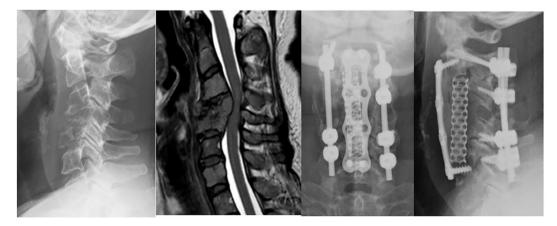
Radiographic study of a 41-year-old woman (patient #39). (A) Plain radiograph lateral view of the cervical spine reveals pathological fracture of C4 with kyphosis. (B) T2-weighted magnetic resonance imaging (MRI) shows spinal metastasis at the C4 vertebral body and circumferential spinal cord compression caused by posterior elements. (C, D) Postoperative anteroposterior and lateral radiographs demonstrate anterior corpectomy of C3-C5 vertebral body and reconstruction using a titanium cage with polymethylmethacrylate (PMMA) augmentation, and stabilization with anterior cervical plate, lateral mass crew, and pedicle screw systems.
